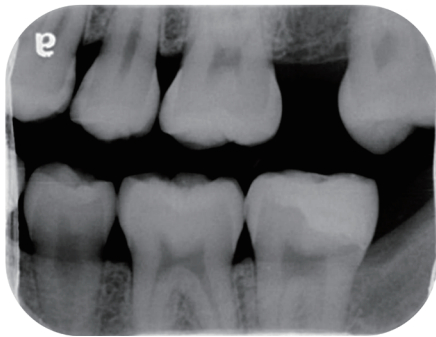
Bitewing film of tooth 37 after the restoration delivered for 2 months.
